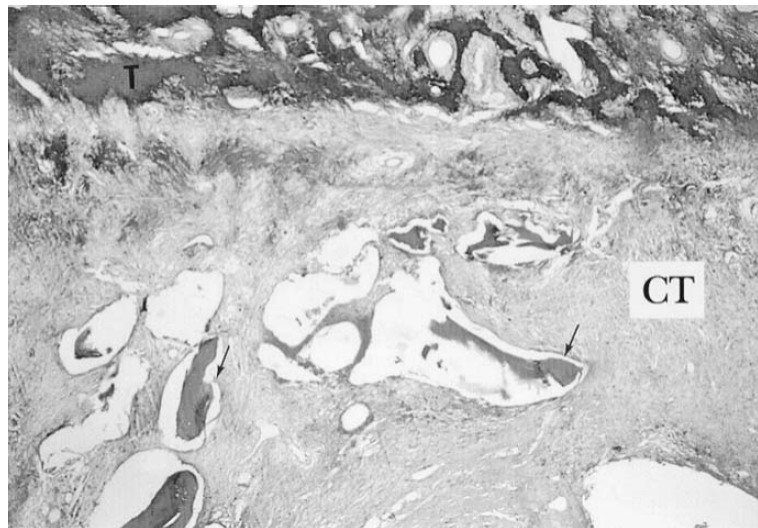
Allogenic bone chips. Dense connective tissue (CT) can be observed in close contact with the new bone trabecules. Trichrome 40X (Michael et al., 2004).
